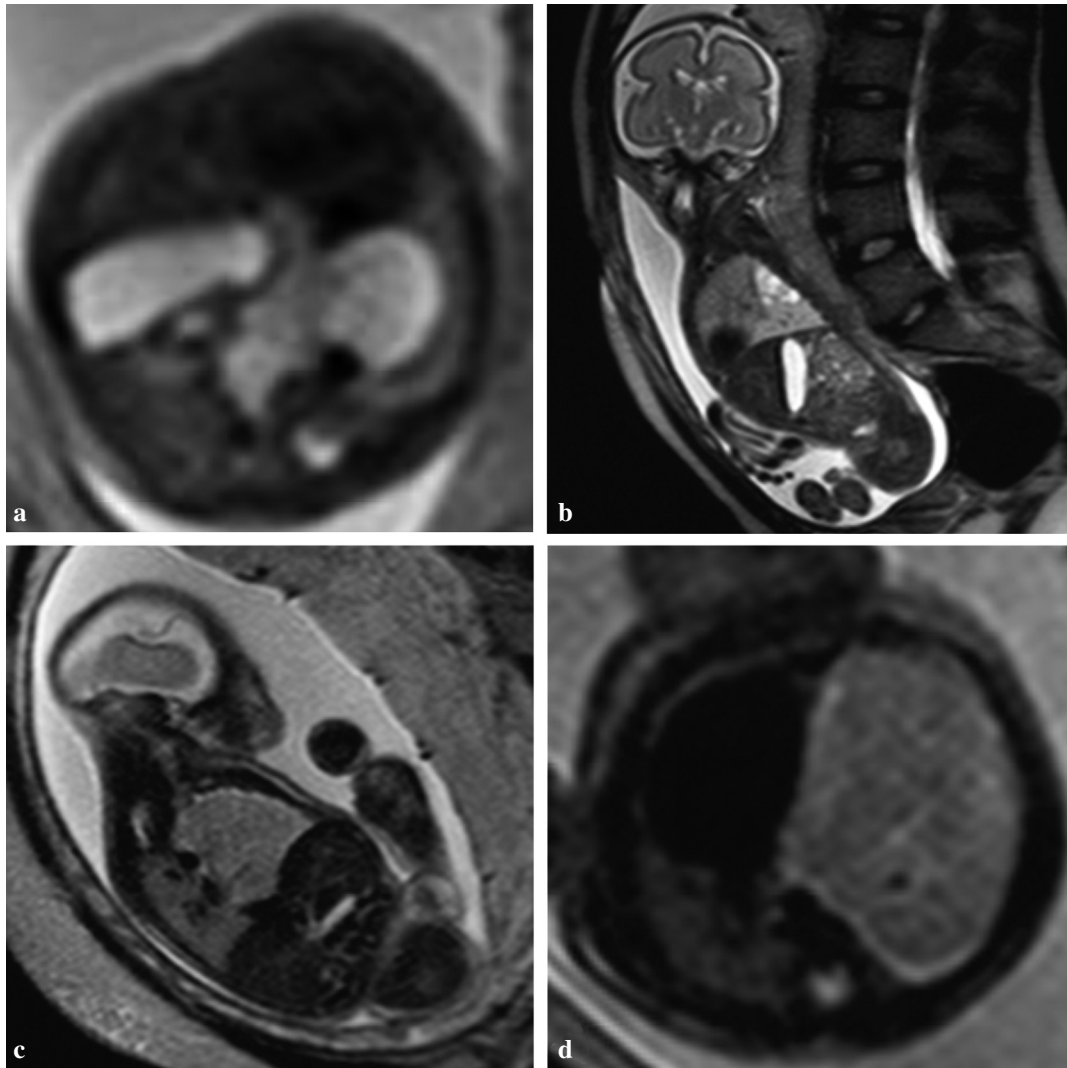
Fetal MRI (a,d) axial, (b) sagittal and (c) coronal T2-weighted MR-images of a congenital cystic adenomatoid malformation of the fetal lung. The 3 different types are shown: (a) type I CCAM, (b) type II and (c,d) type III CCAM.
